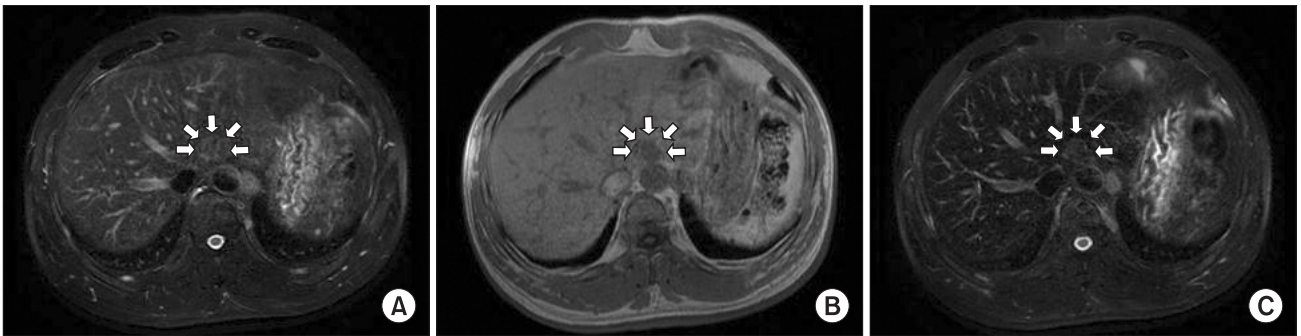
Axial liver MRI. (A) there was a 2.0×1.5 cm sized nodule in segment two of the liver with slightly high signal intensity on the T2-weighted image and (B) low signal intensity on the T1-weighted image. This nodule still showed high signal intensity on the superparamagnetic iron oxide (SPIO) enhanced T2 weighted image (C). MRI = magnetic resonance imaging.
